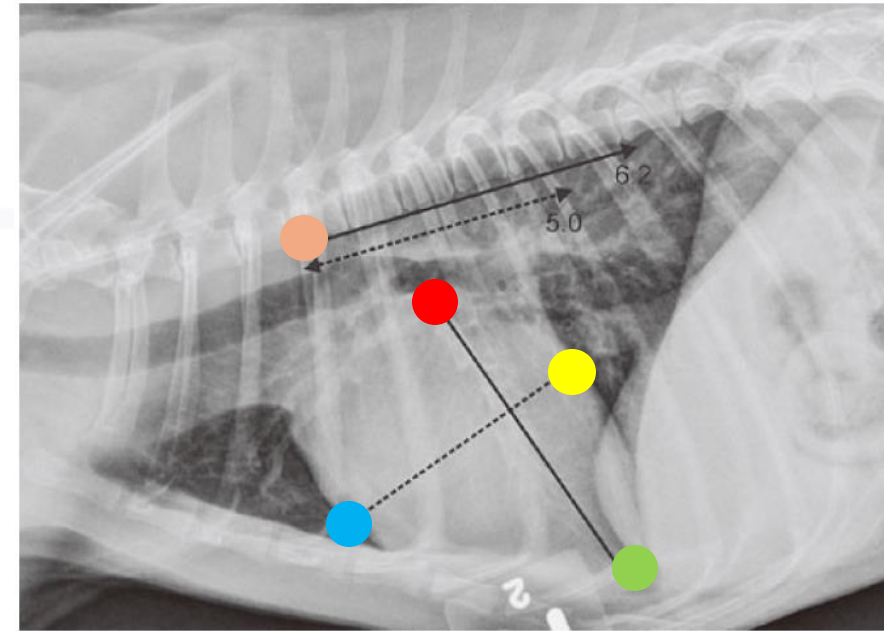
Right lateral thoracic radiograph from a 13-year-old female spayed Toy Poodle demonstrating the vertebral heart size (VHS) measurement technique. The length of the cardiac silhouette is measured from a point ventral to the carina of the trachea to the apex of the heart and the width of the silhouette is measured along the widest portion of the heart perpendicular to the long axis. The ventral border of the caudal vena cava is often used as the starting point for the width measurement. The length and width measurements are compared with the number of vertebral bodies starting from the cranial aspect of the fourth vertebral body. In this instance, the length of the silhouette is 6.2 vertebra and the width is 5.0 vertebra, yielding an overall VHS of 11.2.
